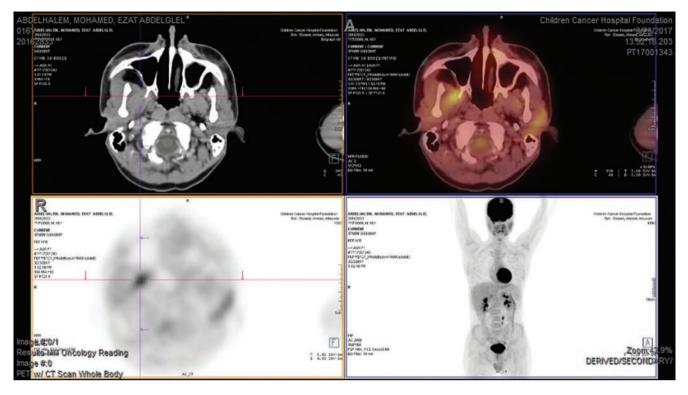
Axial and MIP images of PET/CT and fused18F-FDG-PET/CT images of the same patient's post induction phase showing partial response of the mandibular lesion SUVmax 4, the patient was scored according to 5-ps as score 4
